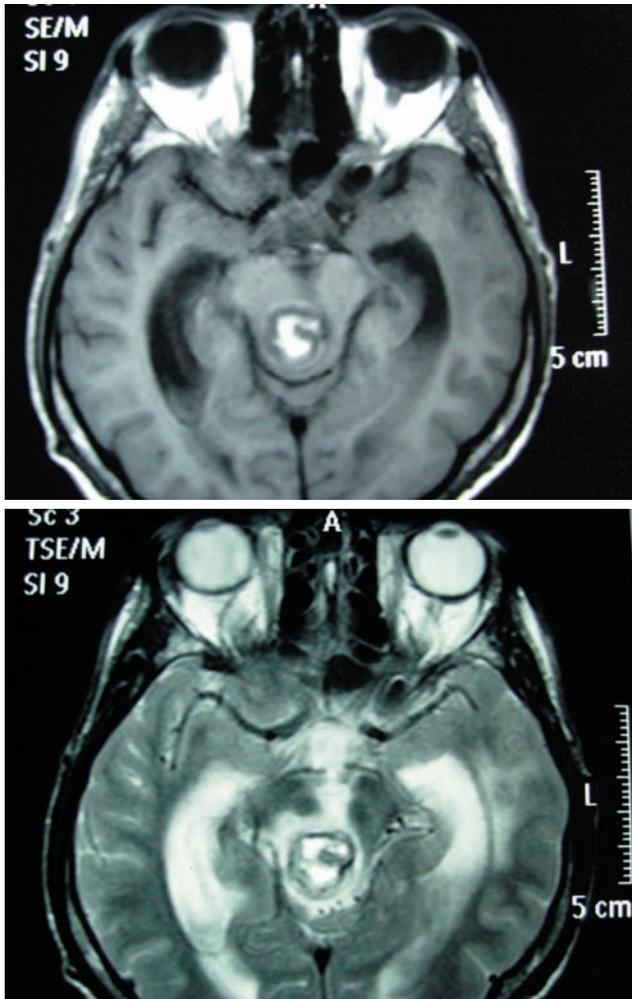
T1-weighted (a) and T2-weighted (b) images in the transaxial plane showing solitary mass in the pineal region.
